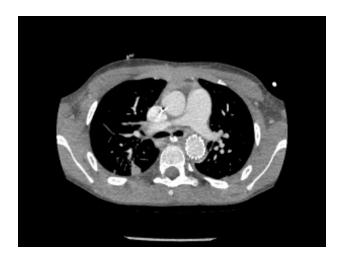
Axial computed tomographic angiogram of the Figure 13.3 patient showing the thoracic stent graft which had been placed, with repair of the injury in the thoracic aorta.
